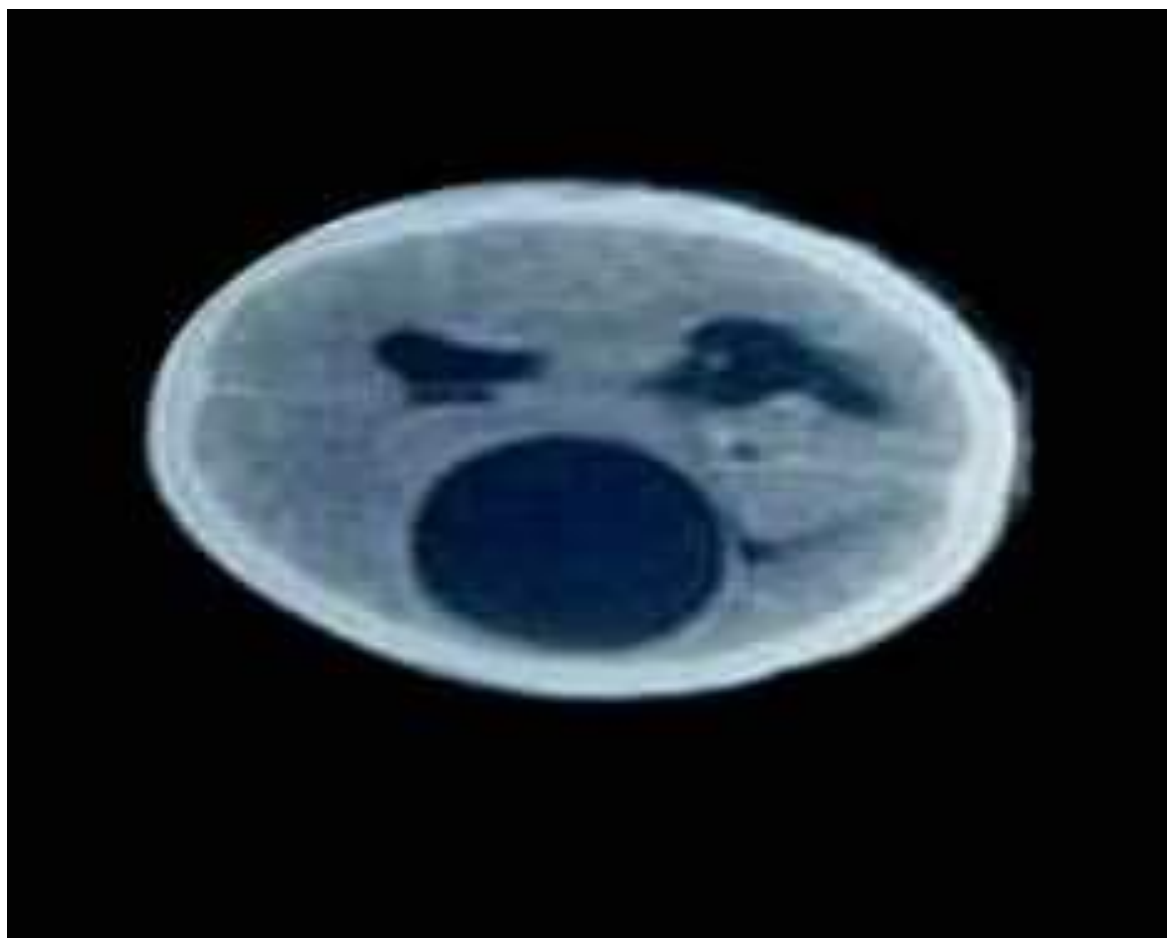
computed tomography (CT) scan showing a very large the right temporo - parietal region of the patient. The cyst is well demarcated , isodense with cerebrospinal fluid ,and causing marked mass effect.
